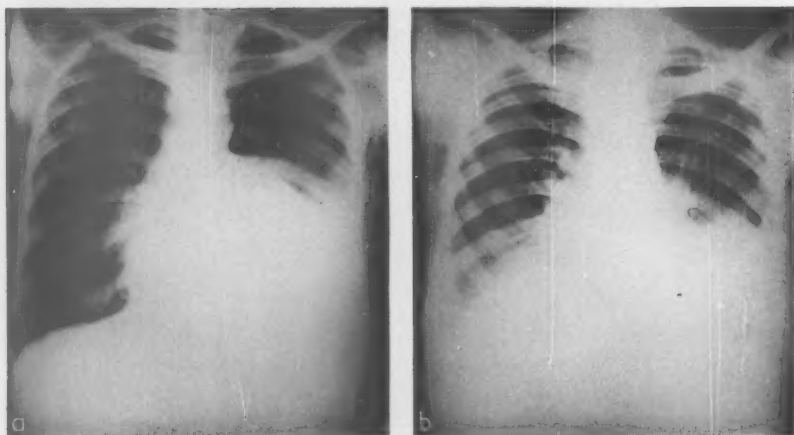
Case 5. (a) Postero-anterior radiograph showing massive pericardial effusion. Note the air instilled after aspiration. (b) Postero-anterior radiograph one month later, after surgical drainage. A left pleural empyema has developed
